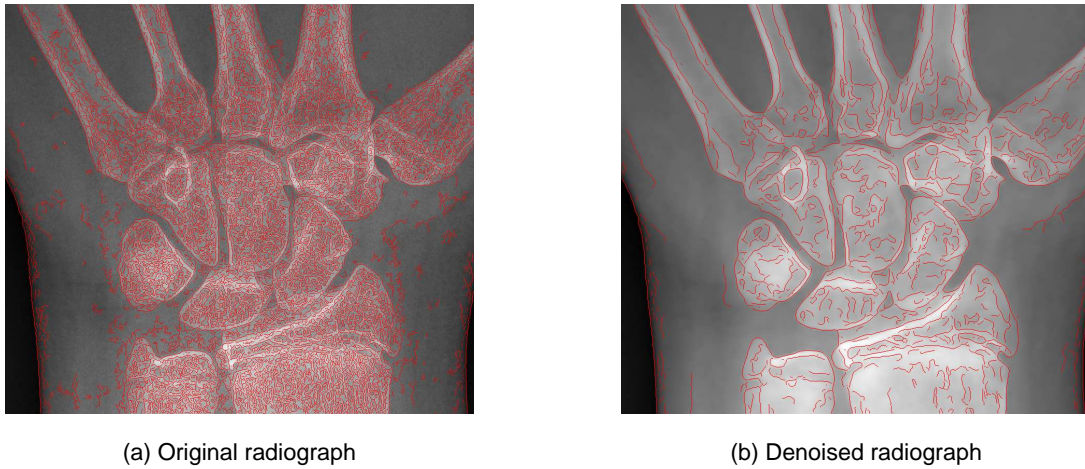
Comparison of the Canny edge detection results for (a) original radiograph, and (b) radiograph denoised using the oriented Laplacians anisotropic diffusion method ($\sigma = 1$ for the Canny edge detector).
